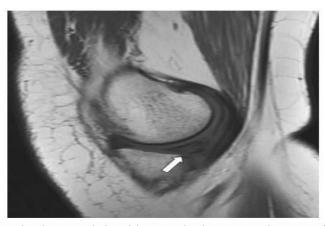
A sagittal T1-weighted image depicts a tear in posterior horn of medial meniscus extending to inferior surface.
